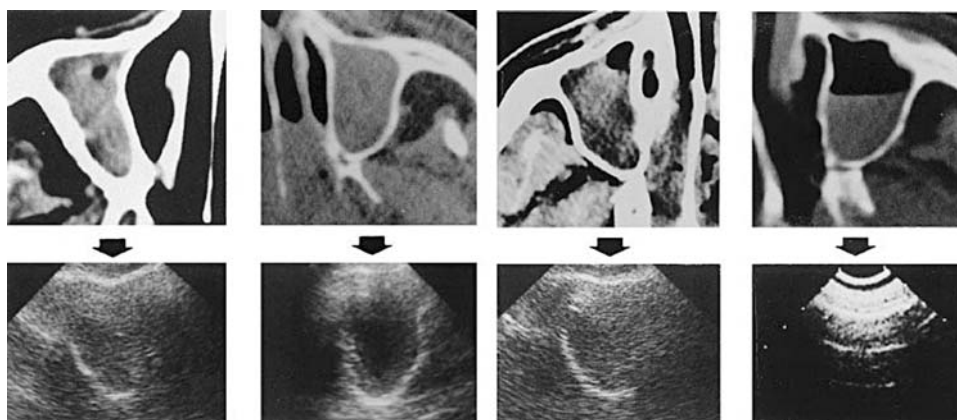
Different abnormal ultrasound patterns. Computed tomography sections of maxillary sinuses are in the upper row with their corresponding ultrasound pattern in the lower row. *From the left to the right:* total opacity of the right maxillary sinus with a small anterior air bubble (the external wall is visible and the internal wall is not visible, giving an incomplete “sinusogram”); total opacity of the left maxillary sinus (the internal, posterior, and external walls of the sinus are visible, giving a complete “sinusogram”); 90% air-fluid level of the right maxillary sinus (the internal wall is not visualized, giving an incomplete “sinusogram”); and 50% air-fluid level of the left maxillary sinus (the walls are not visible, giving an acoustic barrier, and thus no “sinusogram”). (Reproduced, with permission, from Lichtenstein D, Biderman P, Meziere G, et al. The “sinuso-gram”, a real-time ultrasound sign of maxillary sinusitis. *Intensive Care Med.* 1998;24:1057–1061. With kind permission from Springer Science and Business Media.)
